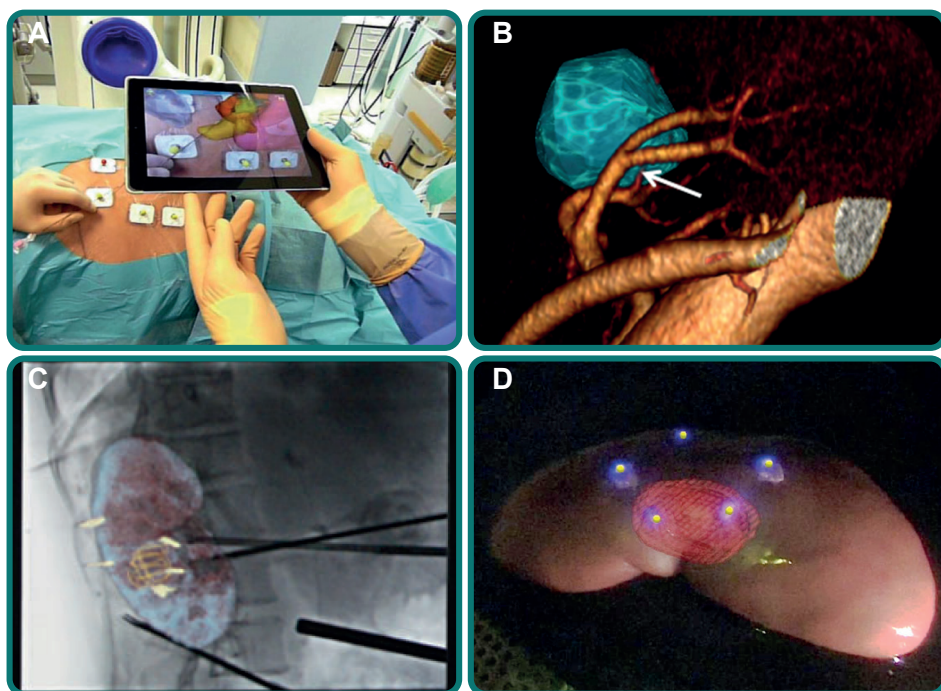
VR and AR technologies for navigation in the urinary system. (a) iPad-assisted percutaneous access to the kidney during nephrolithotomy, providing CT-based AR ‘window in to the body’ [12]. (b) CT-based VR model of renal cell carcinoma, to be used parallel to (RA)LPN, providing insight in the tumor-surrounding vasculature [13]. (c) AR overlay of kidney and tumor models (including intra-abdominal fiducials) in the real-time fluoroscopy images for (RA)LPN [14]. (d) AR overlay of tumor model in the real-time laparoscopic-feed using metabolizable and fluorescent fiducials [15].
